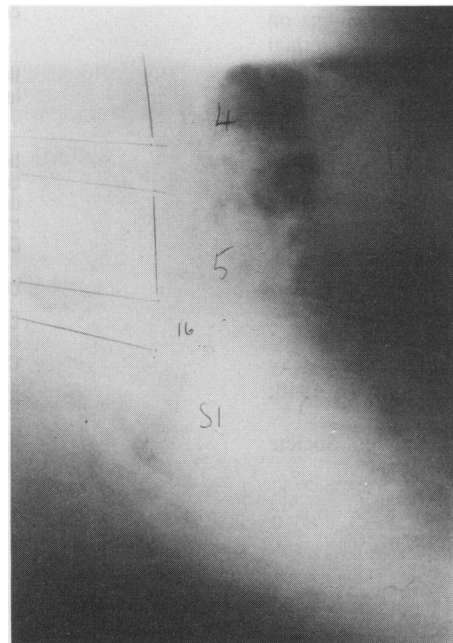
Patient #3. Pre-Inversion radiograph.
